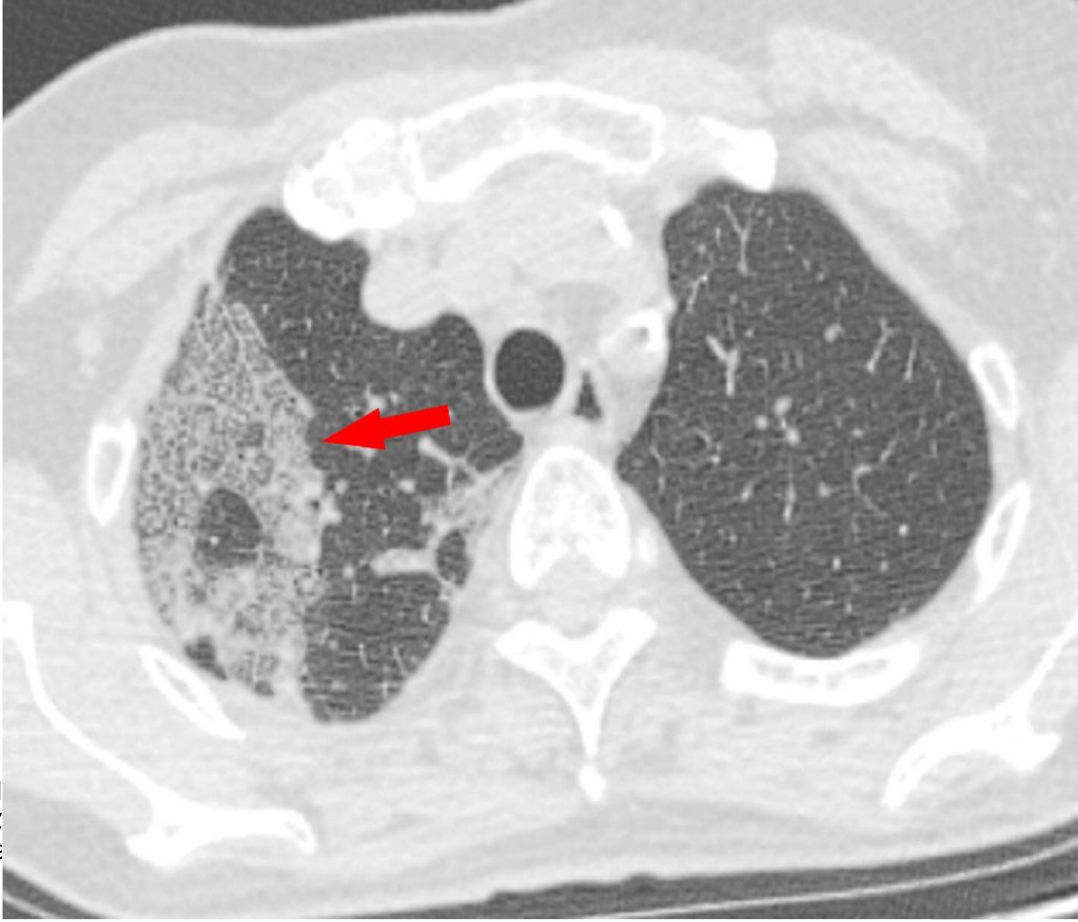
CT findings of conf
